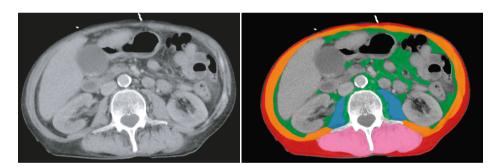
Example of an area analysis of CT-BCPs on the L3 level of a CT scan
